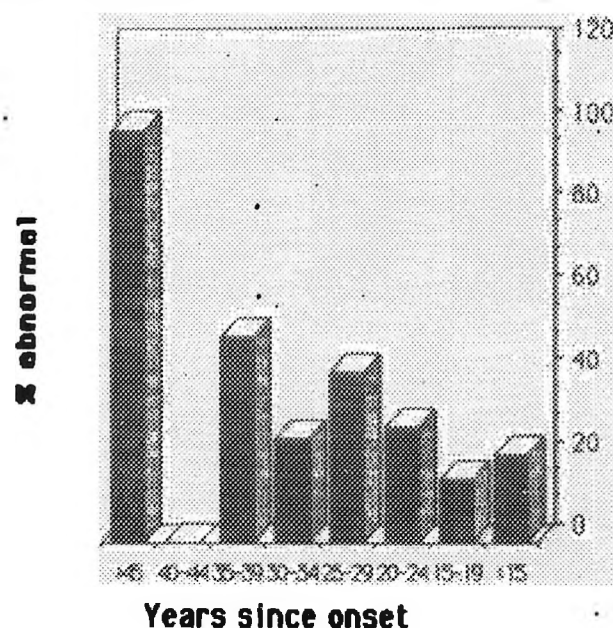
Radiographic findings and time since onset of custodial work among custodians with exposure to asbestos only in New York City Board of Education schools.
